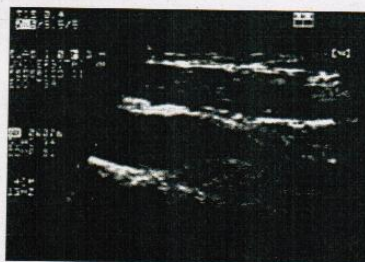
Ultrasound B-mode images of echolucent carotid plaque with luminal narrowing greater than 80%.
